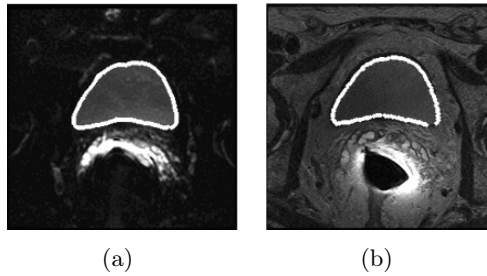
Segmented bladder on the DWI image (a) and T2 image (b).*
